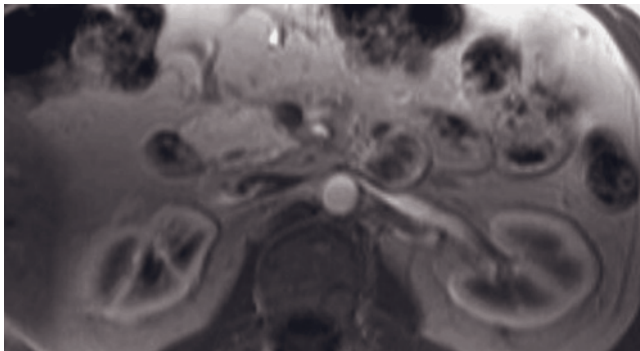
(Continued) SGE (*i, m*), and T1-weighted postgadolinium fat-suppressed interstitial-phase SGE (*j, n*) images demonstrate bilateral pheochromocytomas in another patient. The lesions show high signal on T2-weighted images (*g, k*) and progressive heterogeneous enhancement on postgadolinium images (*i, j, m, n*). Central necrosis is present in the lesions. Note that an extra-adrenal pheochromocytoma (arrow, *k*) is also present.
